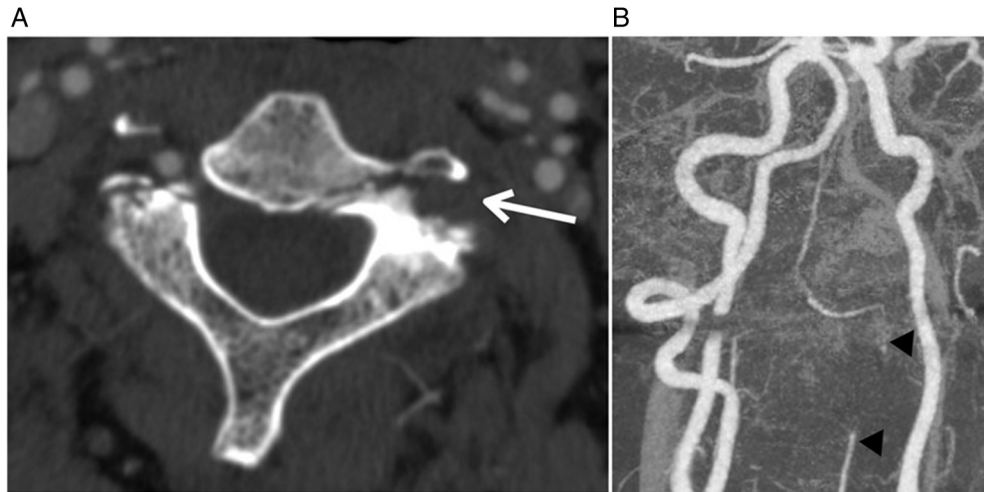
(A) Axial view of CTA showed a filling defect consistent with left VA occlusion (arrow) at admission. (B) 3D-CTA showed the occluded segment (arrowhead) of the left VA and no traumatic changes at the right VA. CTA: computed tomography angiography; VA: vertebral artery
